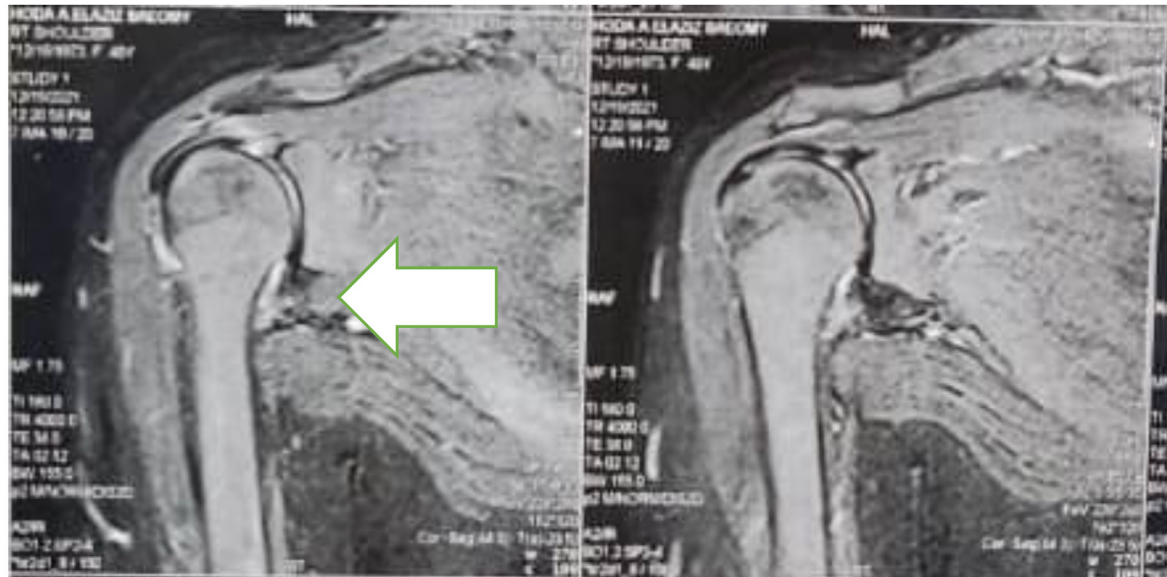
MRI of a frozen shoulder of 40-year-old patient with white arrow pointing at an abnormally thickened inferior glenohumeral ligament and the axillary pouch is contracted and poorly distended and arthroscopic images of the affected site with white arrow pointing at adhesions of the capsule.
